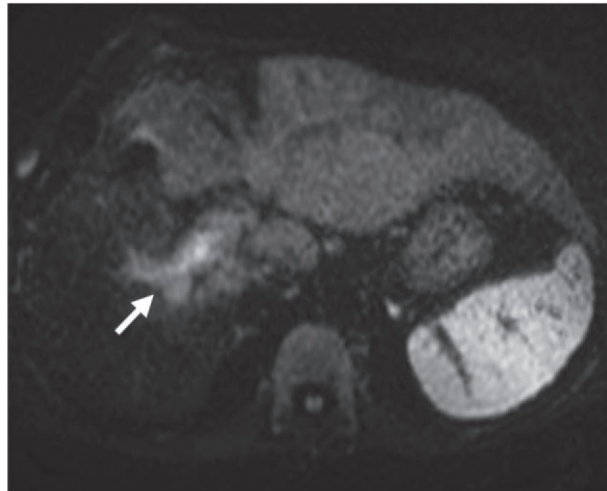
Infiltrative HCC in a 67-year-old man with a history of excessive alcohol use and portal venous thrombosis found at CT performed for follow-up of aortic aneurysm. The patient had a markedly elevated serum AFP level (6880 ng/mL). MR imaging was performed before and after intravenous injection of gadoteric acid. (a) Axial arterial phase T1-weighted MR image shows patchy areas of heterogeneous enhancement diffusely involving the left lobe and posterior segment of the right lobe and extending to the right portal vein (arrow). (b) Axial portal venous phase T1-weighted MR image shows heterogeneous washout appearance, with improved delineation of portal venous tumoral thrombosis (arrow). (c) Axial hepatobiliary phase T1-weighted MR image obtained 20 minutes after contrast material injection shows hypointensity of the involved areas; note the biliary excretion of contrast material (arrow). (d, e) Axial T2-weighted (d) and diffusion-weighted ($b = 500 \text{ sec/mm}^2$) (e) MR images show mild hyperintensity in the involved areas. (f) Transverse US image obtained before MR imaging shows findings of cirrhosis, including heterogeneous echotexture and nodular margins without a focal lesion.
